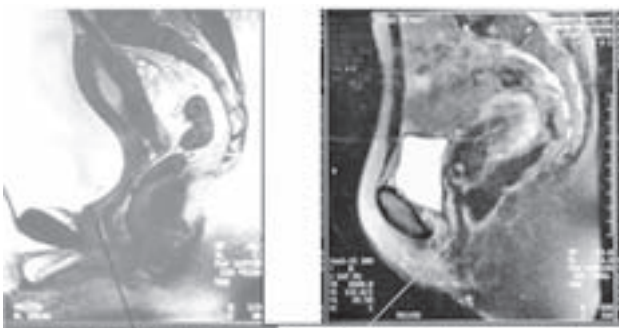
A comparison of MRI coronal sections, of a normal internal urethral sphincter on the left, compared to a torn internal sphincter with a wide urethra on the right, with funneling of the upper part and a flask-shape appearance of the lower part.
